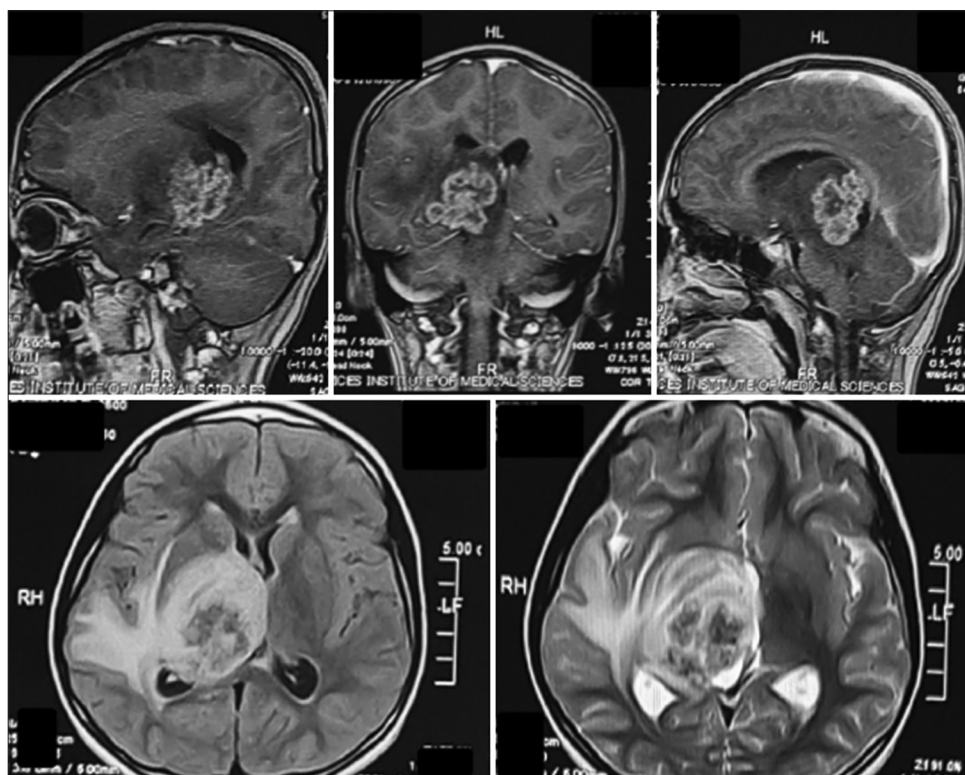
Top row T1 contrast; (bottom left) Fluid attenuated inversion recovery (FLAIR) sequence; (bottom right) T2 sequence. From radiology report – An ill-defined intra-axial heterogeneous lobulated lesion with crenated margins demonstrating patchy contrast enhancement, returning T2 and FLAIR signals involving the right thalamus, posterior limb of the internal capsule, the right half of the midbrain, ipsilateral temporal lobe, hippocampal region, and abutting the splenium of the corpus callosum. There is marked perilesional vasogenic edema. The lesion exerts a mass effect on the body and trigone of the ipsilateral and third ventricles.
